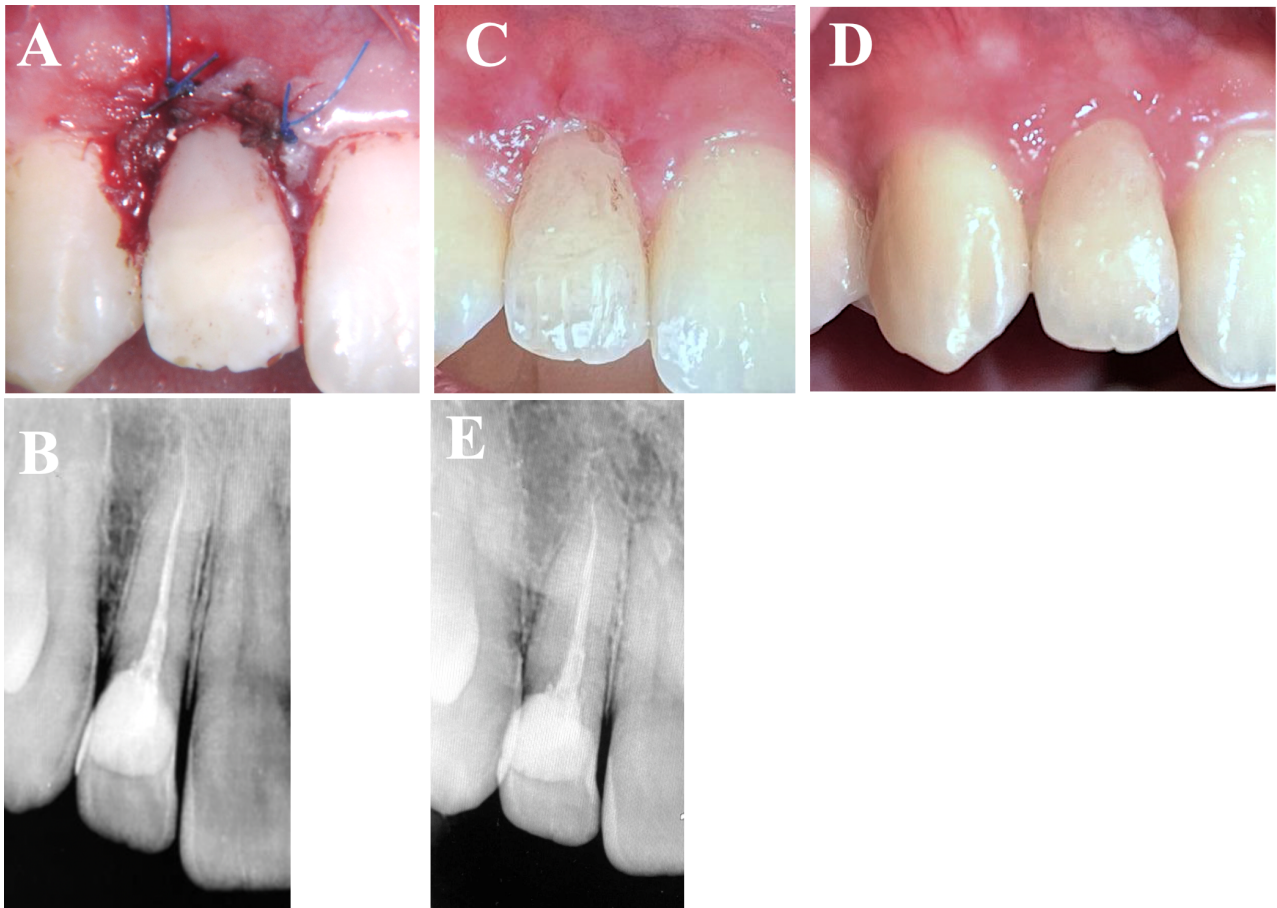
Post-treatment and follow-up images. (A) Postoperative photograph showing sutures. (B) Postoperative radiograph. (C) Clinical examination at the 15-day follow-up. (D) Clinical evaluation at the one-year follow-up. (E) Radiographic assessment at the one-year follow-up.
